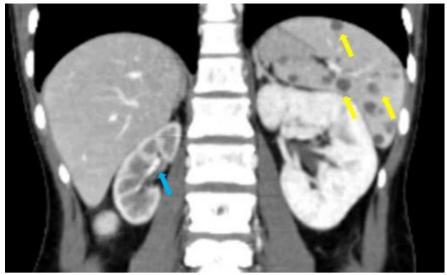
CT-scan of abdomen, axial view. Right kidney (blue arrow), smaller in size and more pallor on nephrogram compared to contralateral kidney; splenic abscesses (yellow arrows).
